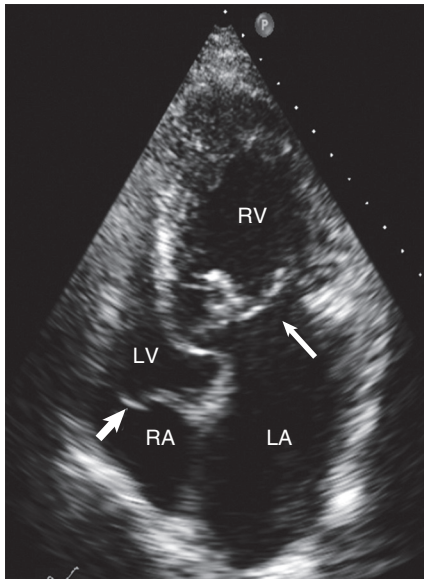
Apical four-chamber view in a patient with L-TGA. The ventricles are inverted with the right ventricle (RV) to the right identified on the basis of its heavy trabeculation and tricuspid atrioventricular valve (*thin arrow*). Although the insertion of the tricuspid valve is always apical to that of the mitral valve, in this case the offset is accentuated consistent with the Ebstein anomaly. Unlike isolated Ebstein anomaly, that seen with L-TGA does not have a sail-like leaflet or adherence of the septal leaflet to the septum. The *heavy arrow* points to the mitral valve. LA = left atrium; LV = left ventricle; RA = right atrium.
